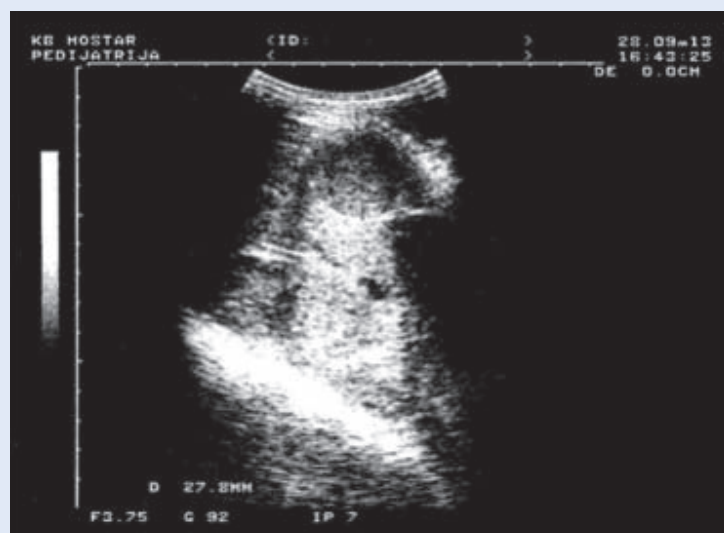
Ultrasound scan of Wilms tumor in right kidney
